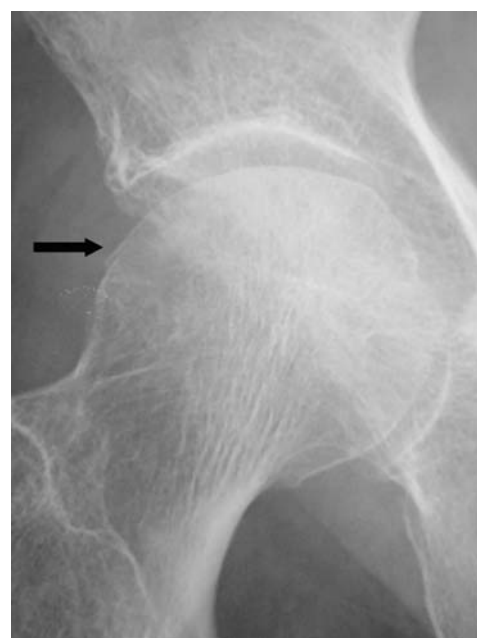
An anteroposterior radiograph of the right hip 4 weeks after onset of pain showing a crescent sign (arrow) at the superolateral portion of the femoral head
